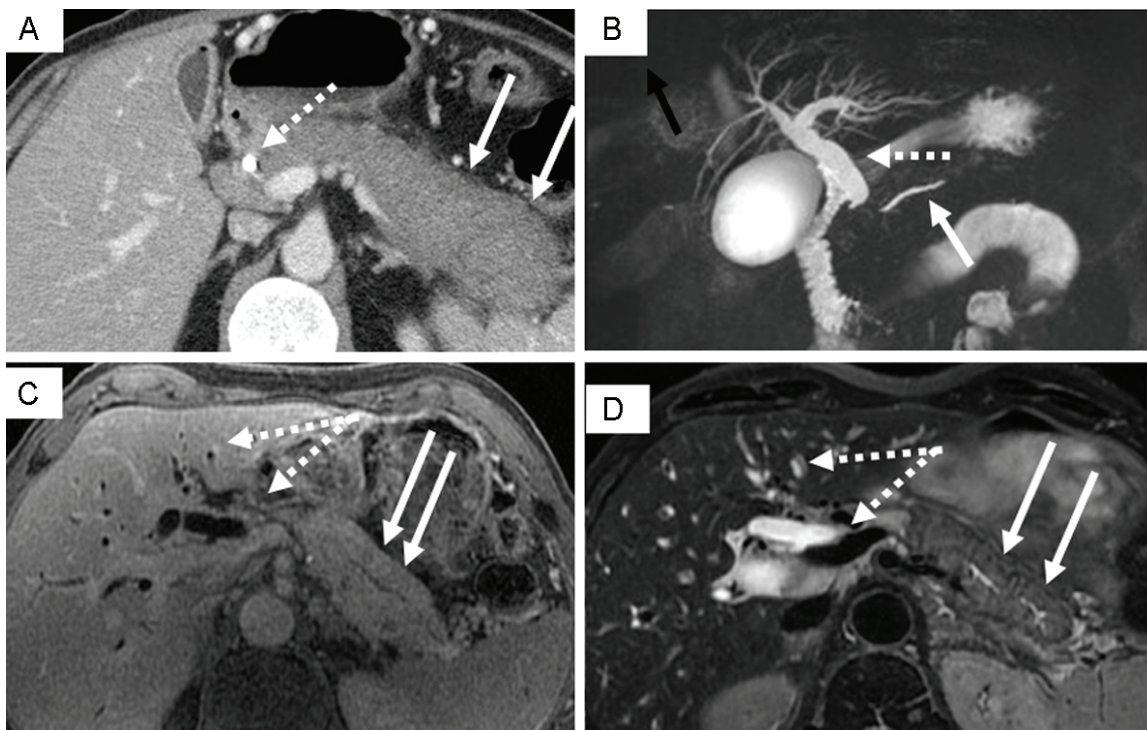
Panel A. Contrast enhanced CT demonstrates diffuse enlargement of the pancreas (“sausage pancreas”) with loss of normal contour and diminished enhancement (solid white arrows). An internal biliary stent is present (dashed white arrow). Panel B-D are MRI images. Panel B. Coronal MIP HASTE image from MRCP demonstrates a diffuse pancreatic duct stricture in the head and tail with a mildly dilated isolated duct segment in the body (solid white arrow). Note extra- and intra-hepatic biliary dilatation from CBD stricture (dashed white arrow). Panels C and D. T1W and T2W axial MR images show diffuse enlargement of the pancreas with loss of contour consistent with autoimmune pancreatitis. Note diffuse irregularity of the main pancreatic duct due to stricture (solid white arrows) and biliary dilatation (dashed white arrows).
